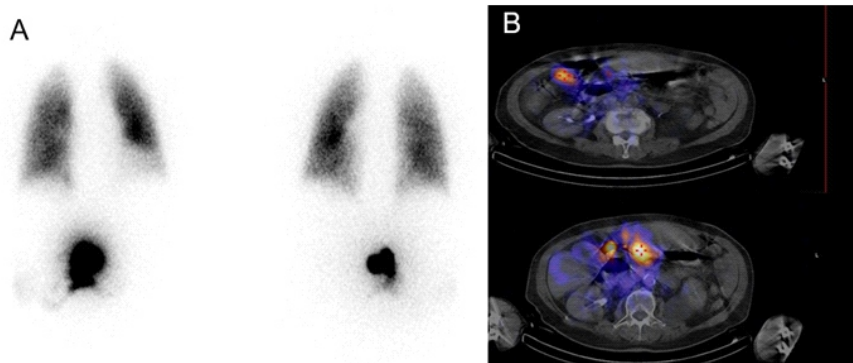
Significant Lung-Shunt precluding treatment. Planar images (A) of a patient with L-S > 45%. The same patient had leak to the gut identified in SPECT/CT images (B) only. Single photon emission computed tomography/CT increases accuracy for leak identification.
